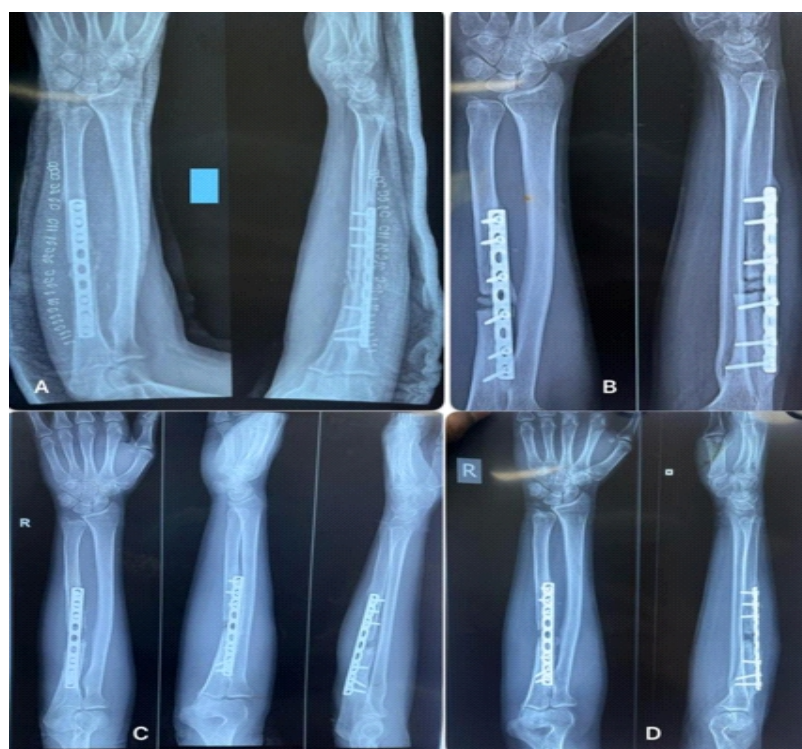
Serial radiographs (a, b, c, d) of the patient subsequent to the second surgery after K-wire removal and compression plating. The fracture did not have compression, and the cancellous graft subsequently was resorbed. The construct failed because the forearm fractures heal by a cutting cone mechanism, and contact and compression of the two ends of the fracture are prerequisites for the same.
